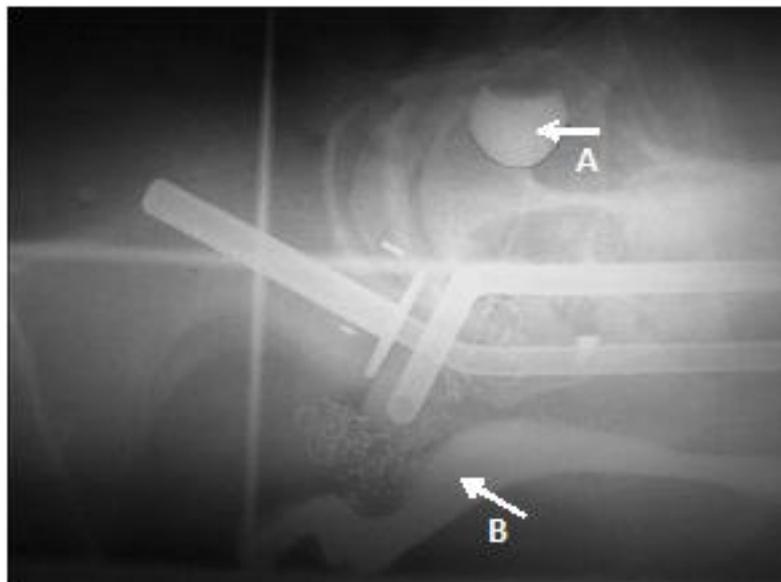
Lateral x-ray showing intracavitary brachytherapy with the remote after-loading technique. The circular-shaped vaginal applicator is fixed to the intrauterine applicator. Two silver markers are placed in the cervical tumour. The bladder and the rectum are visualised by contrast medium in the catheter balloon (A) and the rectum (B), respectively
